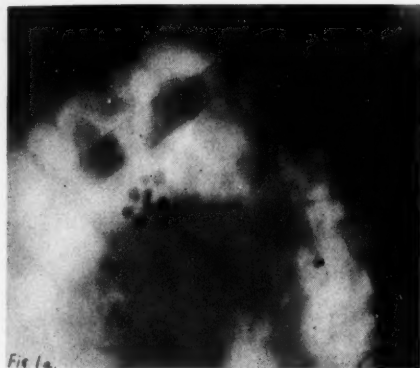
Preliminary clinical diagnosis: acute osteomyelitis. The x-ray film reveals multiple concretions which are suggestive of gall-bladder calculi.
